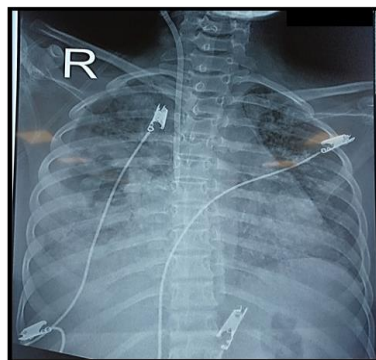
Chest X-ray showing some reduction in consolidation and cavity formation in the right middle lobe (12<sup>th</sup> Day)
